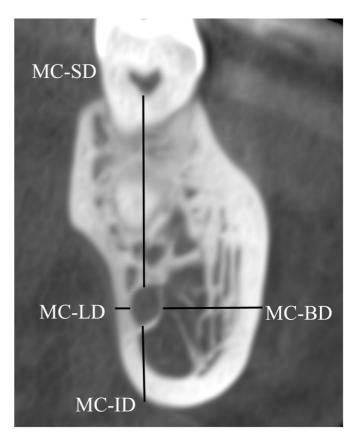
Linear measurements of the Mandibular Canal to the superior (MC-SD), lingual (MC-LD), inferior (MC-ID), and buccal (MC-BD) cortical edges of the mandible on CBCT cross-section images (0.2 mm slice thickness)
